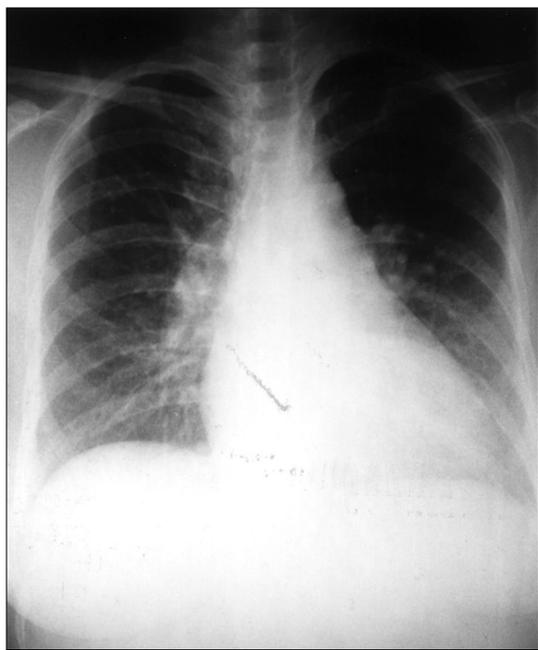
Chest roentgenogram showed cardiomegaly and both pulmonary arterial dilatation with pulmonary vascular cephalization.
